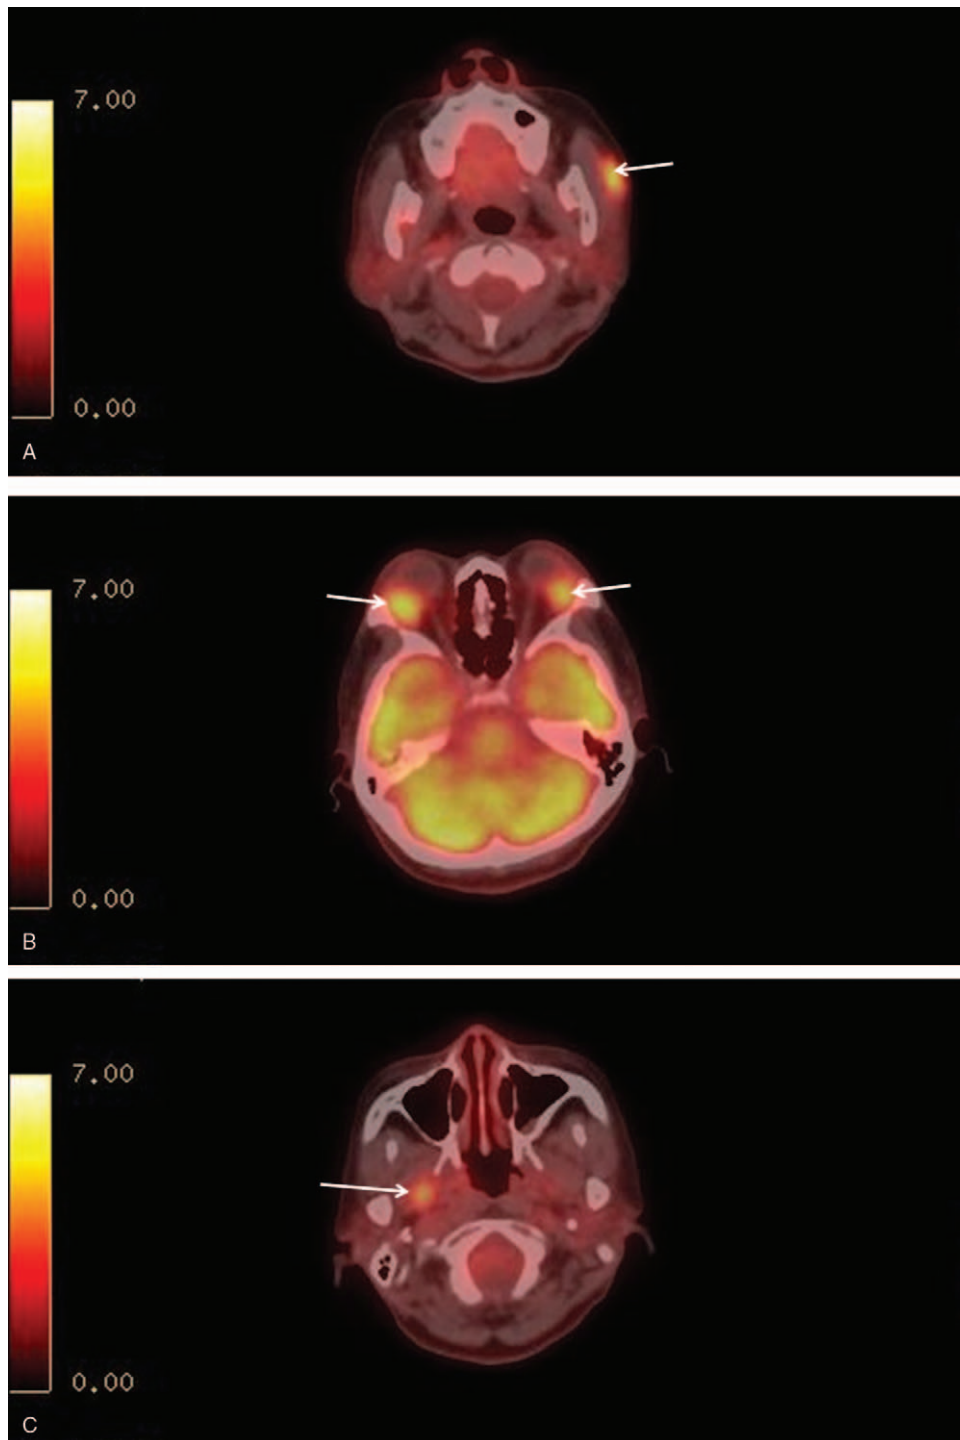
Torso positron emission tomography–computed tomography revealed a focal hypermetabolic lesion in the left accessory parotid gland (A), both lacrimal glands (B), and right retropharyngeal space (C), which was suggestive of lymphomatous involvement.
